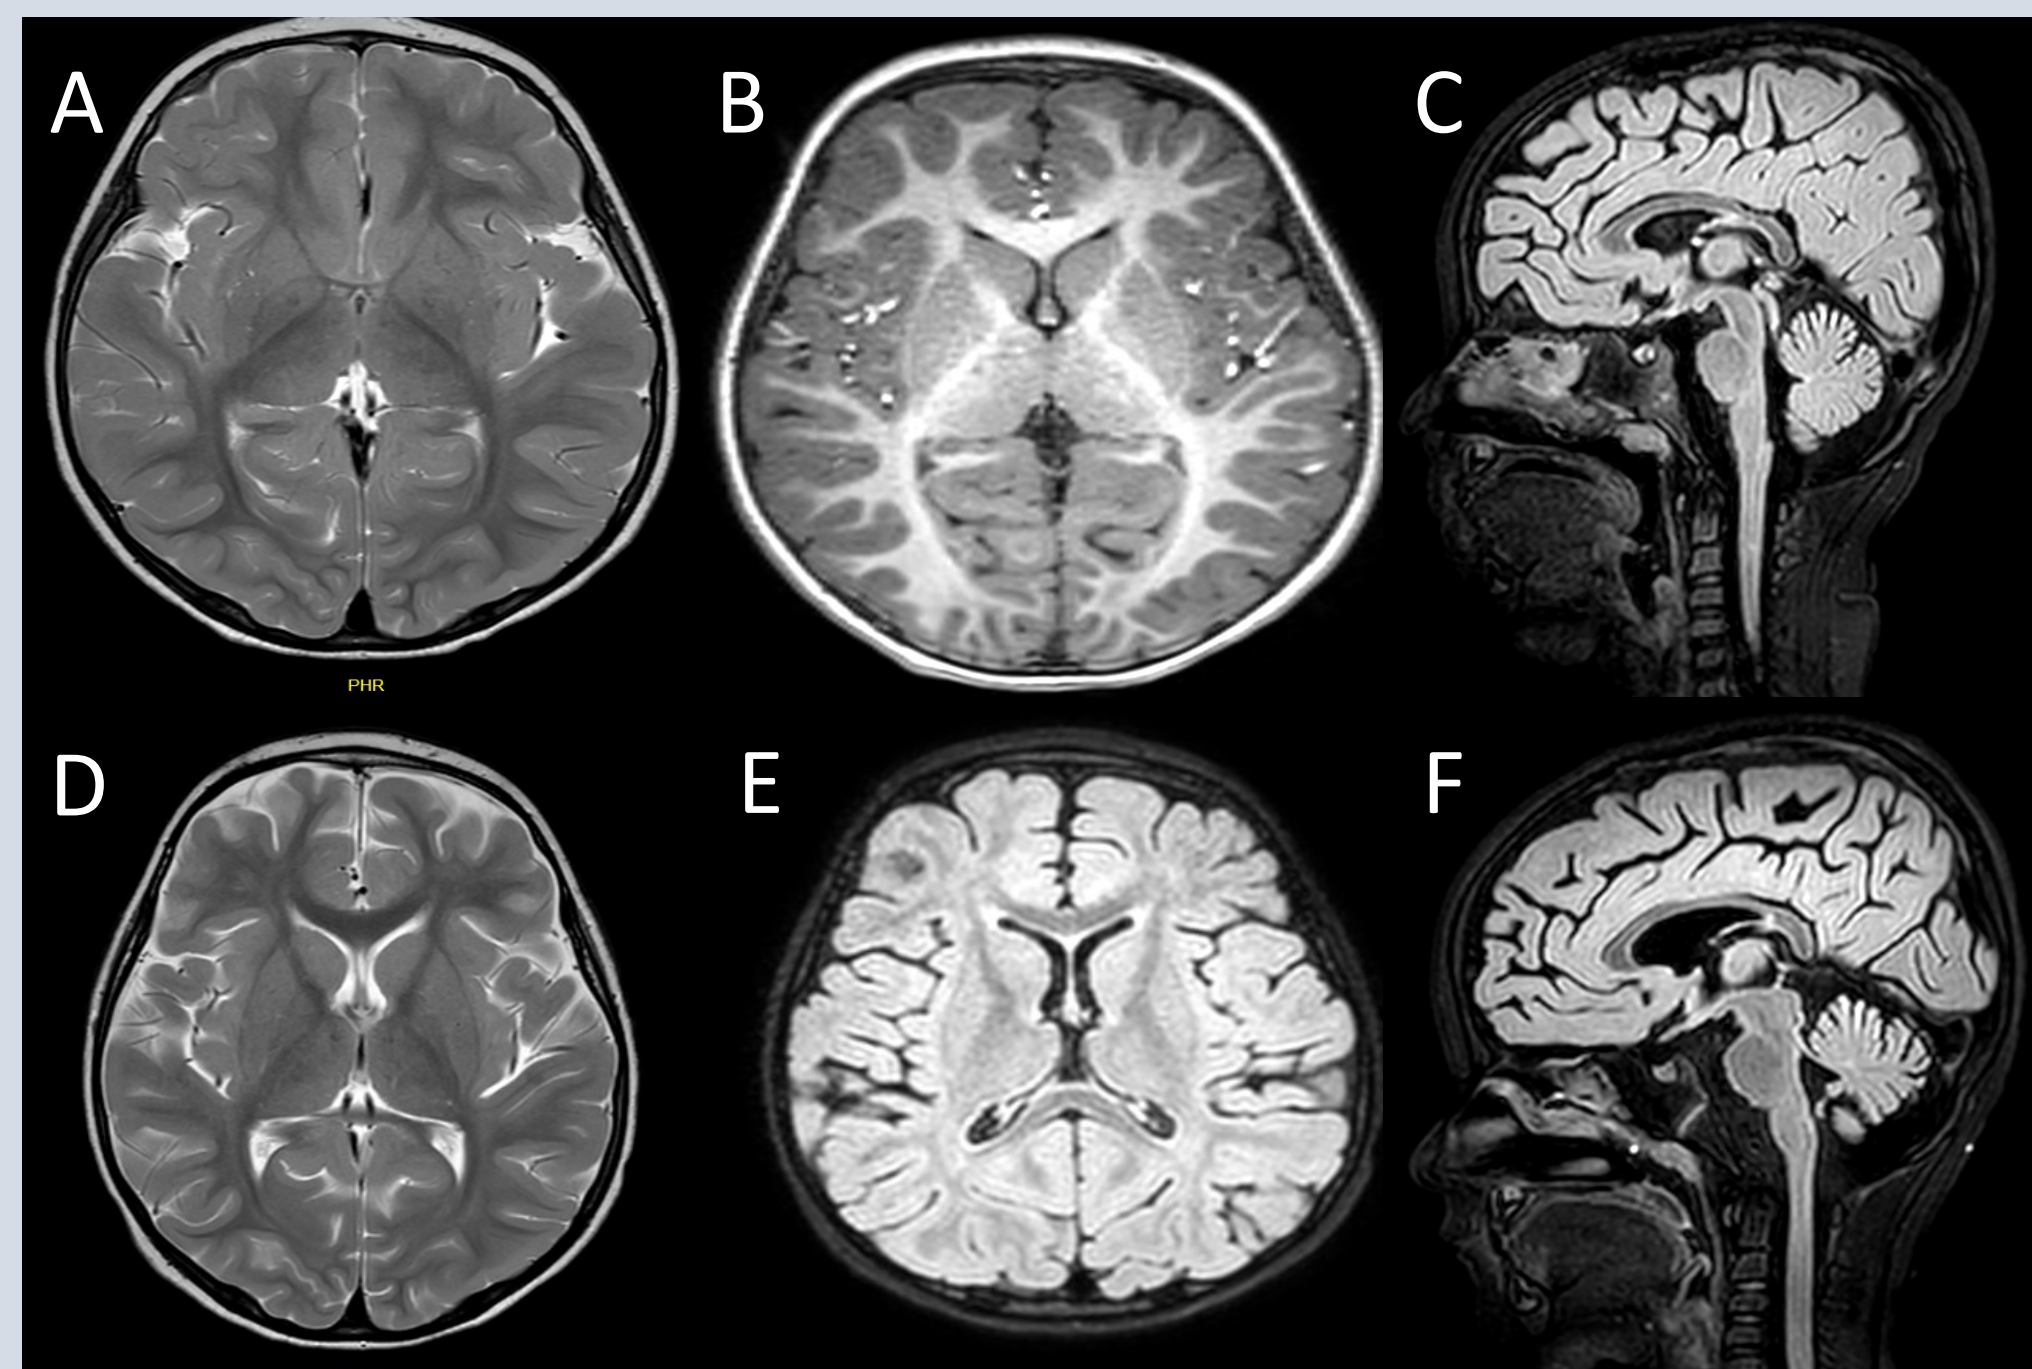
Brain MRI shows mild cerebral and cerebellar atrophy. A-B-C at 2 years, D-E-F at 3 years of age
